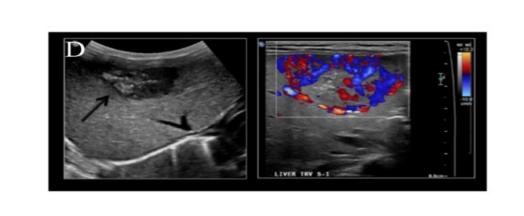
Imaging techniques (MRI, US, and CEUS) utilized throughout this study. Images shown depict BWS patients.
